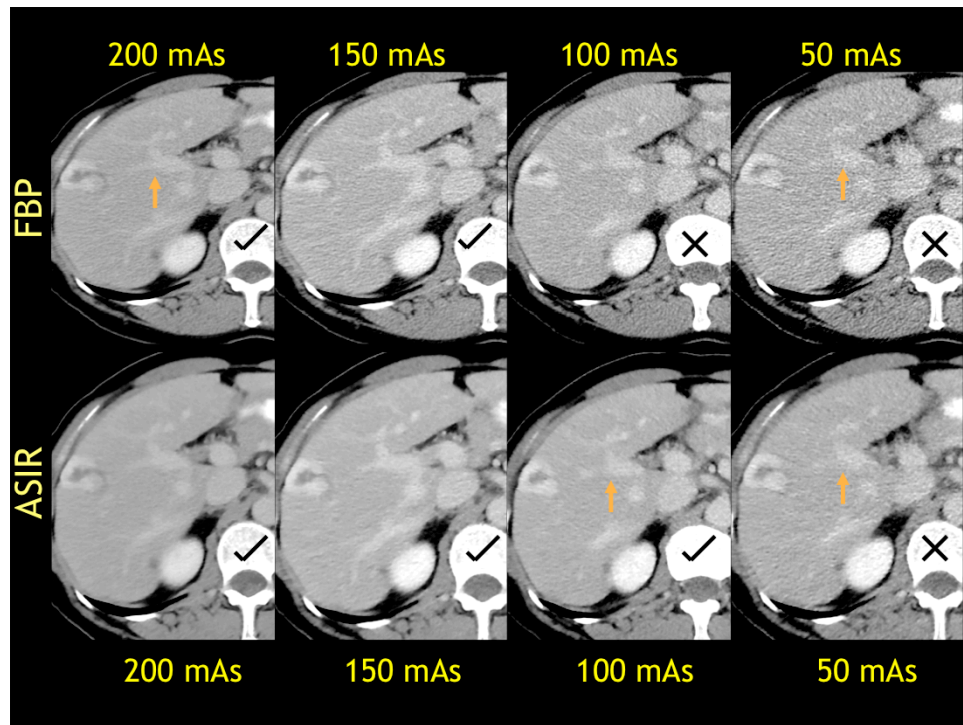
Transverse abdominal CT images in a 51 year old woman (63 kg) with a right hepatic lobe enhancing lesion (hemangioma) in segment 5 was acquired at four tube current levels (200, 150, 100 and 50 mAs) and resultant radiation dose levels (16.4, 12.6, 8.4 and 4.2 mGy) were reconstructed with FBP and iterative reconstruction technique (Adaptive Statistical Iterative Reconstruction, ASIR, GE Healthcare). ASIR enabled images shows lower image noise at each dose levels. However, compared to other dose levels at 4.2 mGy, visibility of the hepatic veins is compromised in both FBP and ASIR images.
